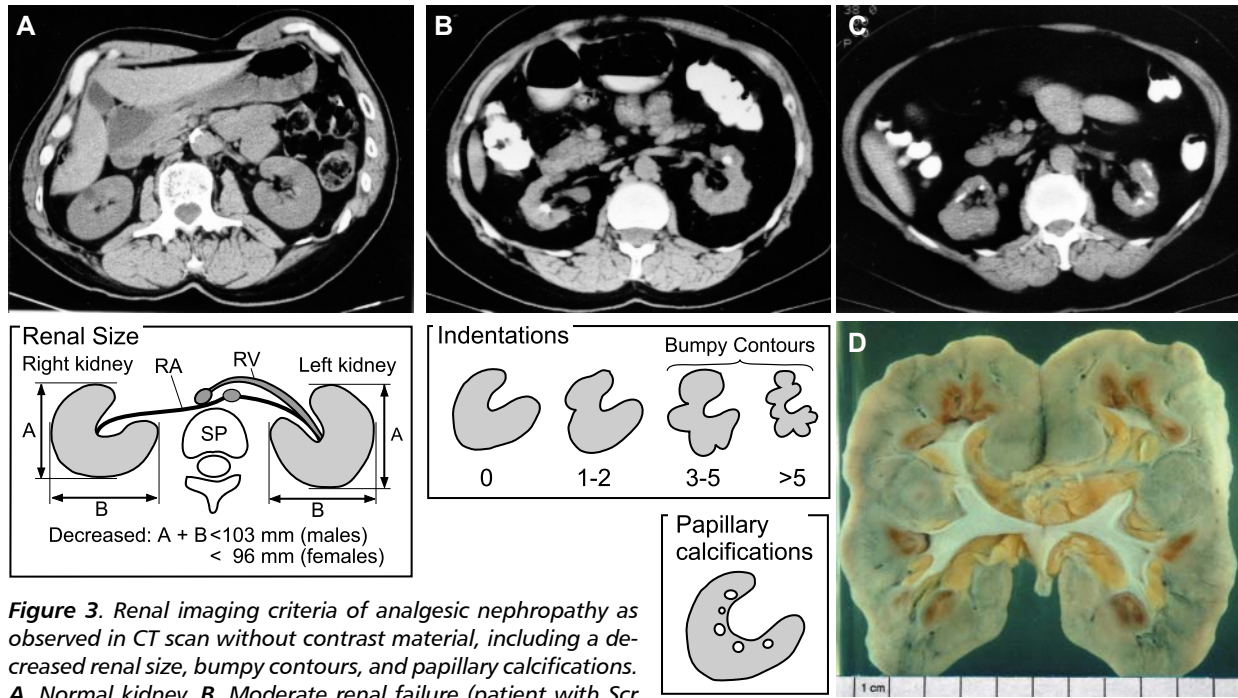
Renal imaging criteria of analgesic nephropathy as observed in CT scan without contrast material, including a decreased renal size, bumpy contours, and papillary calcifications. A. Normal kidney. B. Moderate renal failure (patient with Scr 2.3 mg/dl). C. End-stage renal failure. D. Post-mortem kidney of an analgesic nephropathy patient with moderate renal failure. Irregular contours of the kidney, fibrotic-necrotic foci of papillae. RA= renal artery; RV= renal vein; SP= spine.
